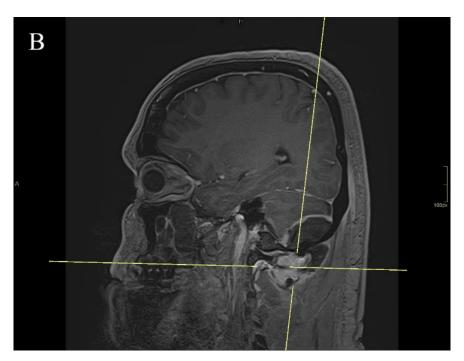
Contrast-enhanced MR images taken after re-admission show extradural collection over the right cerebellar hemisphere causing mass effect with partial effacement of the fourth ventricle $\bf A$) Axial View $\bf B$) Sagittal View
